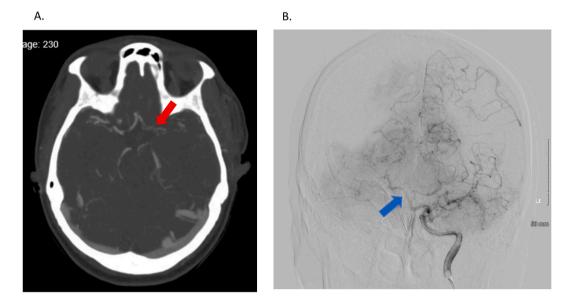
A. Computed tomography shows limited filling of left medial cerebral artery (red arrow) and B. Digital subtracting angiography shows cross-filling through the right anterior cerebral artery (blue arrow) to left anterior cerebral artery and left medial cerebral artery.
